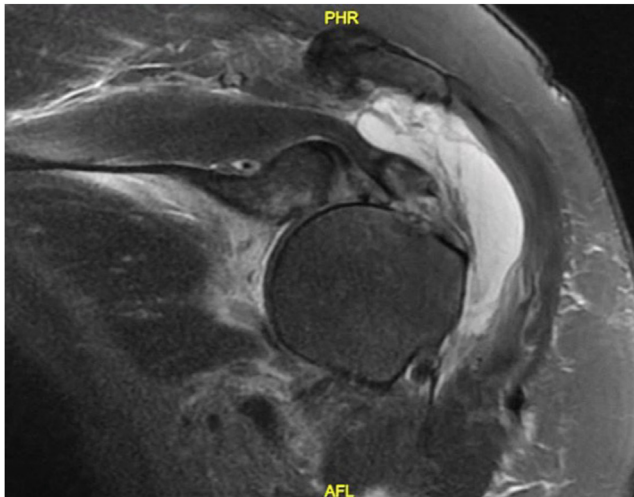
Preoperative MRI with rotator cuff lesion, shoulder dislocation and severe bone loss. MRI, magnetic resonance imaging.
